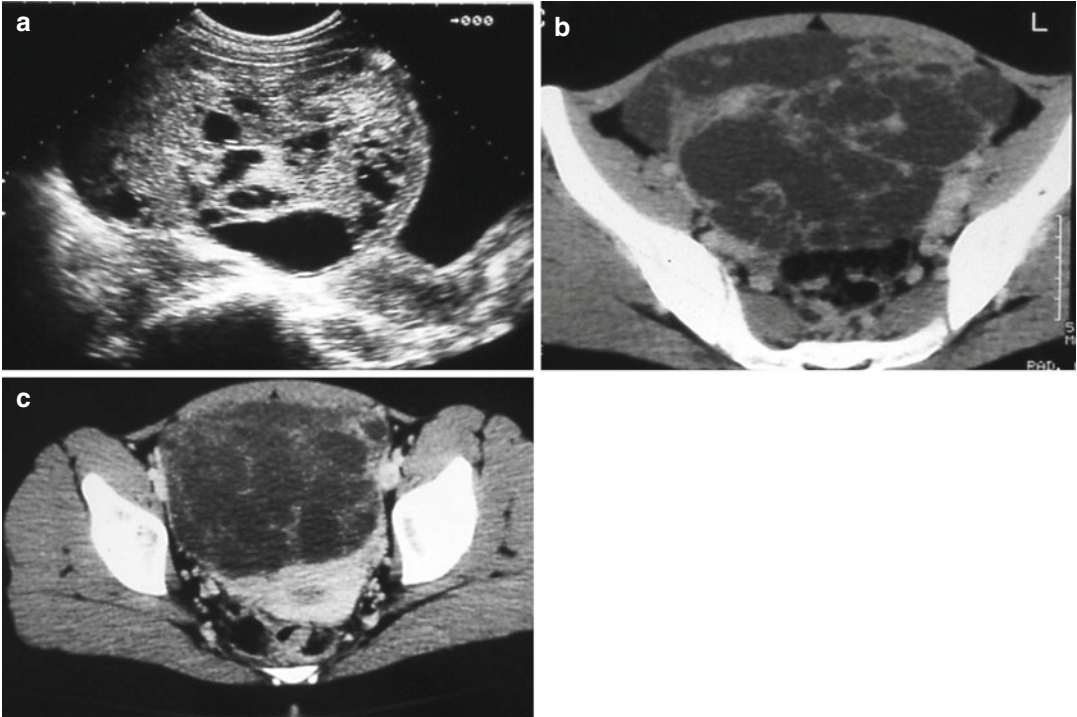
(a) Transverse US in a 13-year-old girl with pain and palpable mass shows a large complex mass into the pelvis. (b, c) Axial contrast-enhanced CT images
